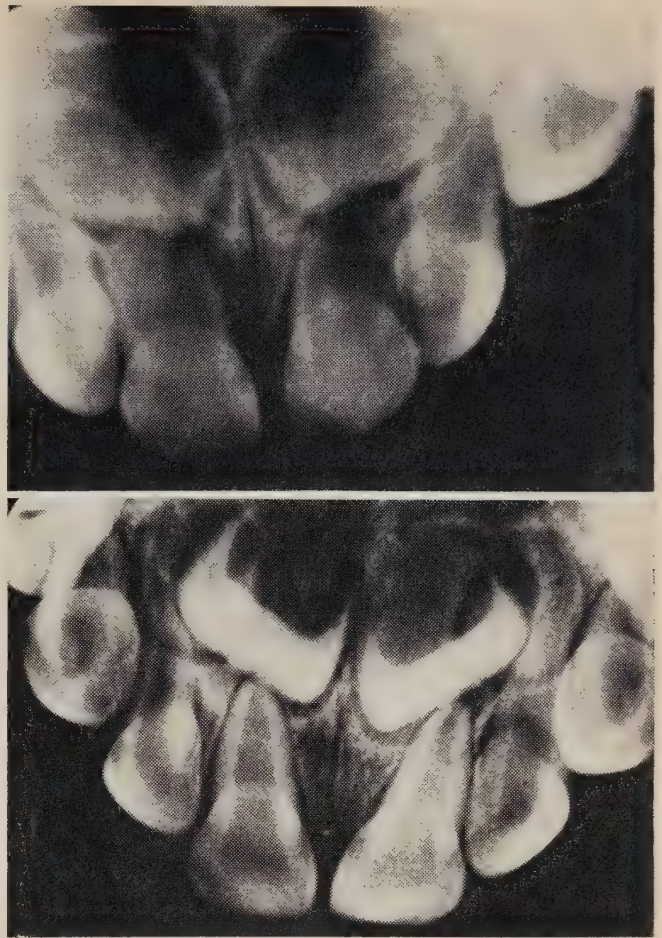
Radiographs show development of permanent teeth in 18 and 24 month old children respectively.
